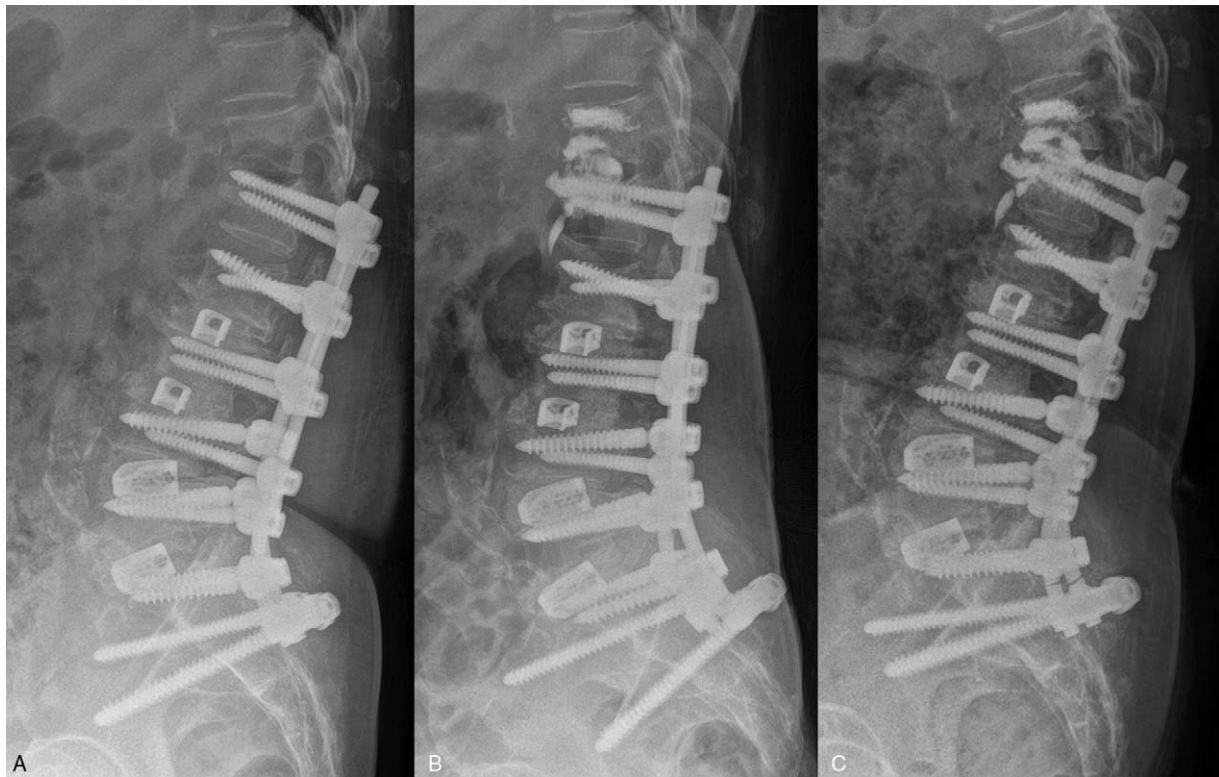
A 69-year-old woman with proximal junctional failure after posterior lumbar interbody fusion (case 7). (A) T12, L1 vertebral body compression fracture and L1 screw pull-out to superior endplate revealed on X-ray. (B) Percutaneous cement injection was performed at the level of the T12 and L1 vertebra bodies and discoplasty at the T12-L1 level. (C) Progression of local kyphosis and T12, L1 vertebral body fractures was seen on X-ray at the last follow-up.
